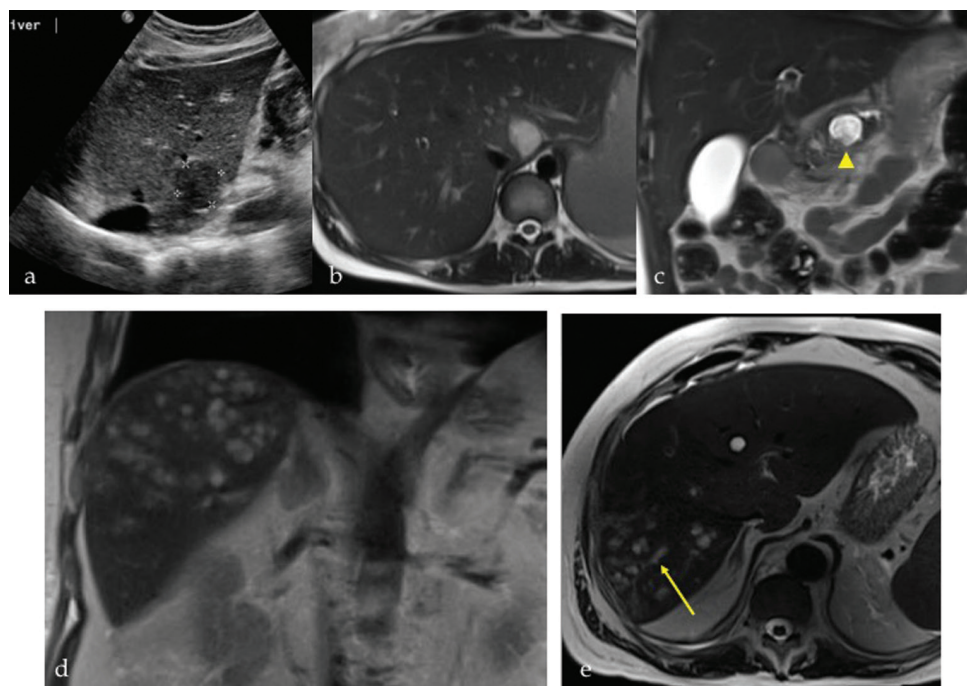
a. Pseudocyst on ultrasound seen as a hypoechoic lesion. b. T2W magnetic resonance imaging shows hepatic pseudocyst. c. Coronal T2W magnetic resonance imaging shows an intrapancreatic pseudocyst in the same patient as b. d and e. Cholangitic abscesses seen as T2 bright lesions clustered around a dilated bile duct (arrow). These are less well-defined than simple cysts.
